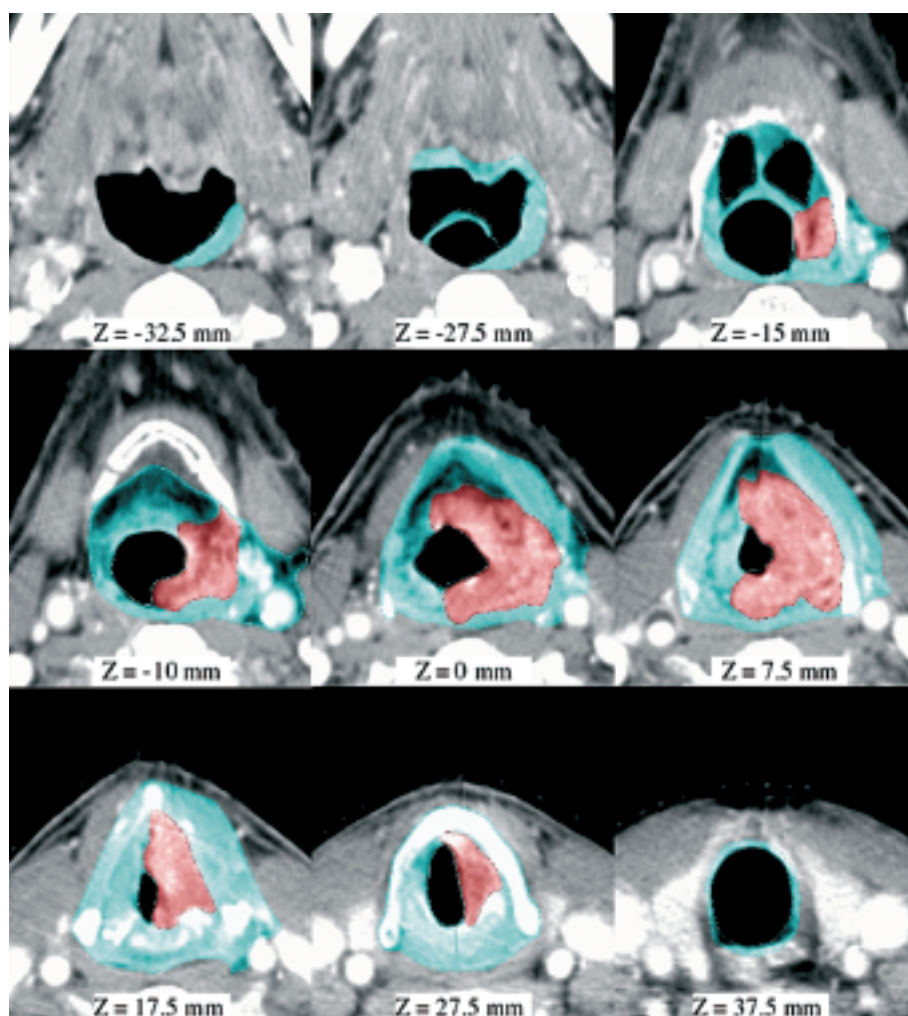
Axial CT slices of a 70y male with a T3 glottic carcinoma (GTV in red) extending from the supraglottis to the subglottis. There is at least an intimate contact between the tumor and the left cricothyroid muscle ($z = 0$ mm) leading to its « secure » inclusion in the CTV (in light blue) from $z = 0$ to 17.5 mm. At $z = -15$ mm, the tumor has reached the three folds region (through the aryepiglottic folds) making it mandatory to include valleculae and homolateral posterior pharyngeal wall constrictor muscles. Piriform sinus and retrocricoid region are included because (1) the tumor reaches the posterior border of the paraglottic space located between the posterior edge of the thyroid cartilage and the arytenoid and (2) the left aryepiglottic fold is largely invaded.
